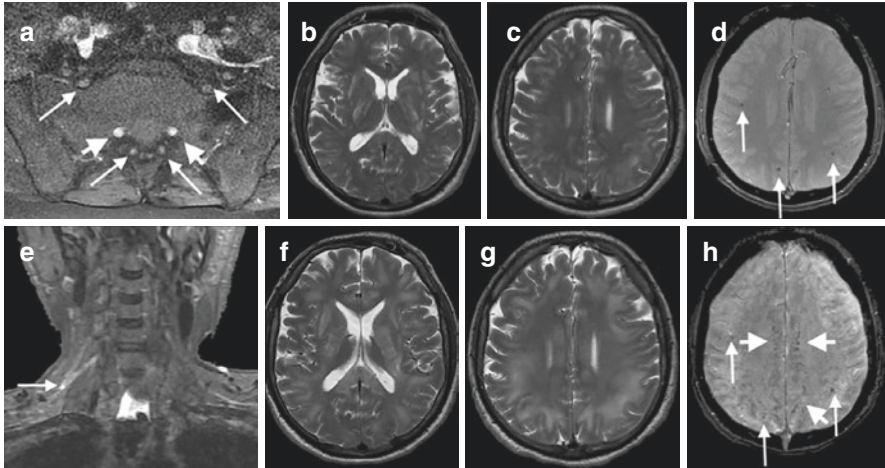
MRI appearances in a case of post COVID ADEM—reproduced with permission from Paterson et al. [29]. (a–h) Patient 16: axial post-gadolinium fat-suppressed T1-weighted images (a) demonstrating pathologically enhancing extradural lumbosacral nerve roots (arrows). Note physiological enhancement of nerve root ganglia (short arrows). Coronal short tau inversion recovery (STIR) image (b) shows hyperintense signal abnormality of the upper trunk of the right brachial plexus (arrow). Initial axial T2 (b and c) and T2-weighted images (d) show multifocal confluent T2 hyperintense lesions involving internal and external capsules, splenium of corpus callosum (b), and the juxtacortical and deep white matter (c), associated with microhaemorrhages (d, arrows). Follow-up T2-weighted images (f and g) show marked progression of the confluent T2 hyperintense lesions, which involve a large proportion of the juxtacortical and deep white matter, corpus callosum and internal and external capsules. The follow-up SWI (Susceptibility-weighted image) (h) demonstrates not only the previously seen microhaemorrhages (arrows) but also prominent medullary veins (short arrows)
